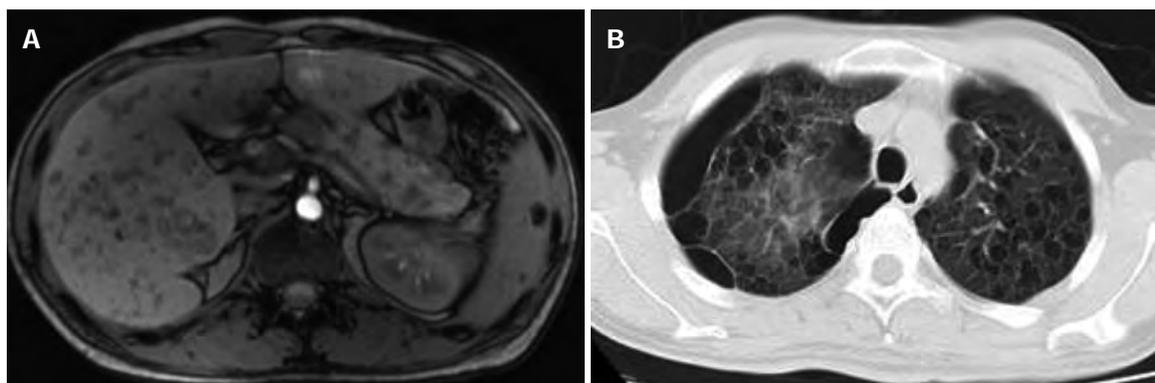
Polycystic lesions in the liver, gallbladder, pancreas, and spleen, and retroperitoneal lymphadenopathy and bullae. A: Abdominal magnetic resonance imaging figure showed diffuse swelling; B: Computed tomography findings image of lung.
